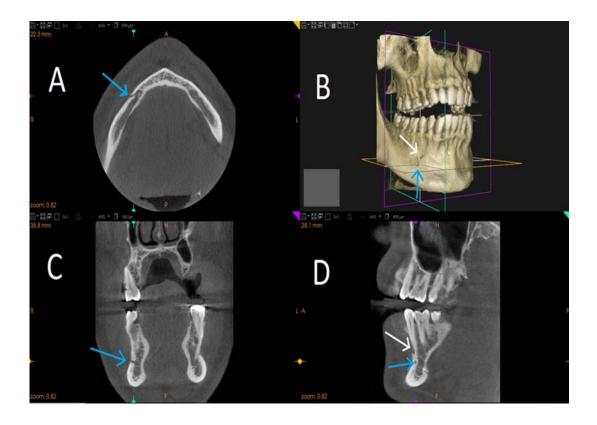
cone beam computed tomography images of the mental and accessory mental foramen. A- Axial section image. B- three-dimensional image. C- coronal section image D- sagittal section image. blue arrowhead - mental foramen, white arrowhead - accessory mental foramen
